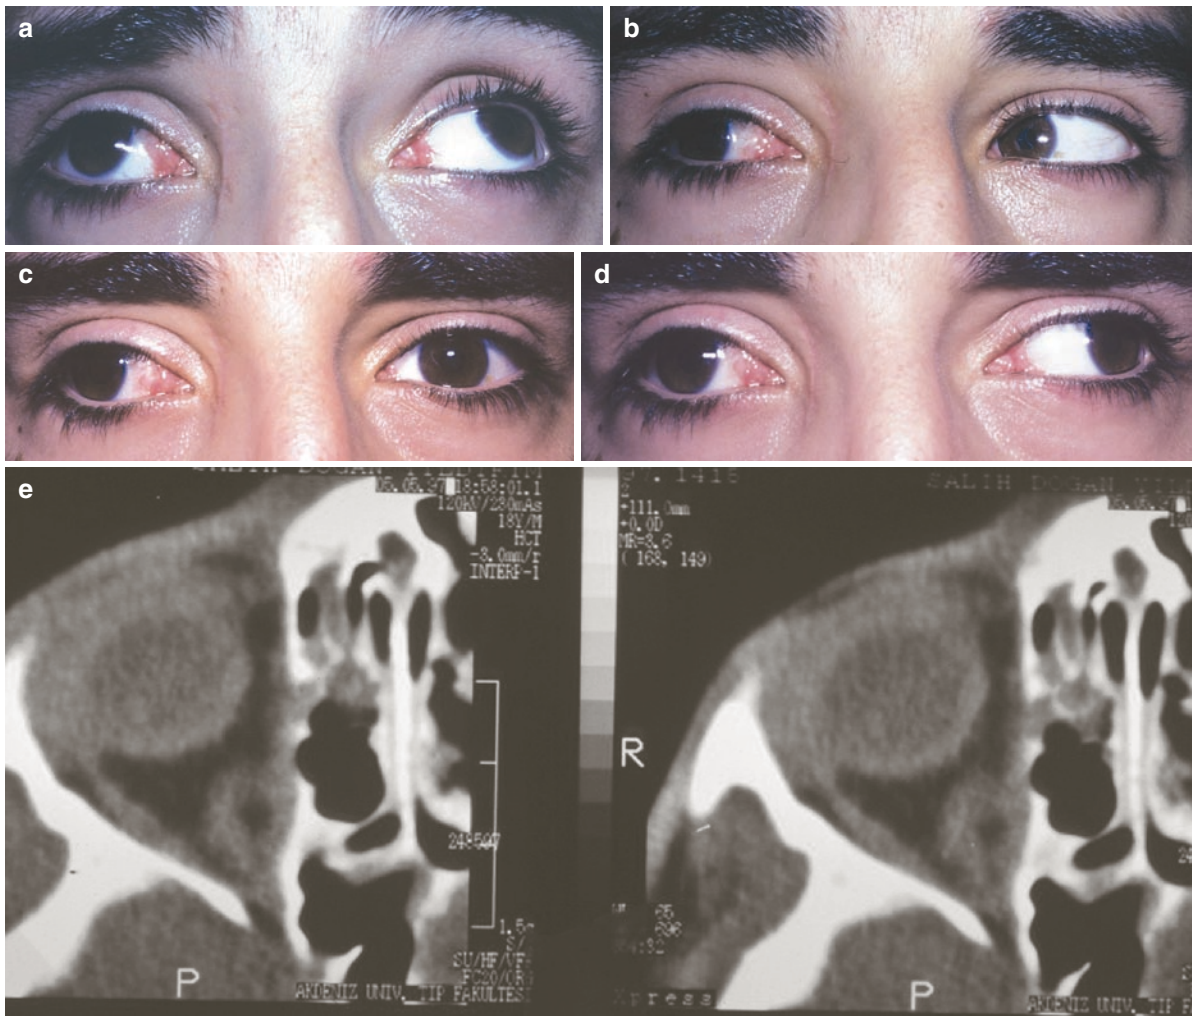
(a–d) Left medial rectus muscle injury on the right side during endoscopic sinus surgery. There is strabismus to the lateral side and impaired mobility of the eye. (e, f) Axial CT scans show the injury (courtesy of Şener)
